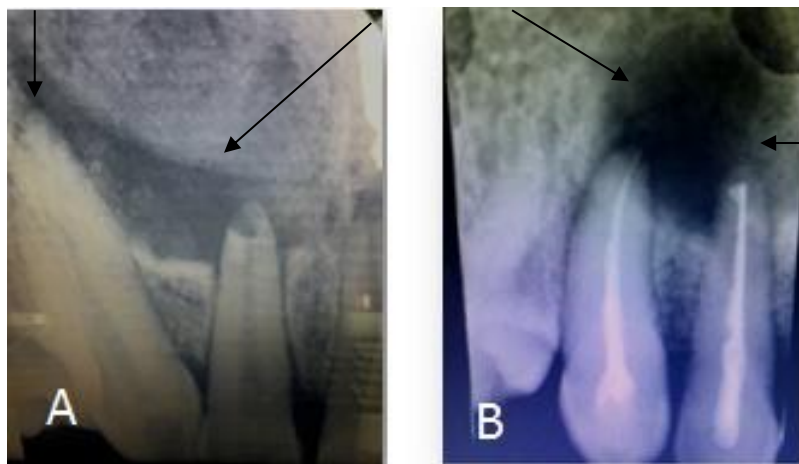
(A,B): Intraoral periapical radiographs of one cases in presented study
